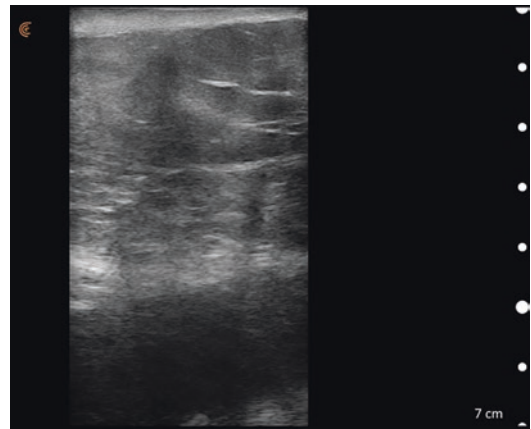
Grayscale ultrasound image of edema of the abdominal wall. Diffuse hyperechoic shadows obscure the normal hypoechoic soft tissue
